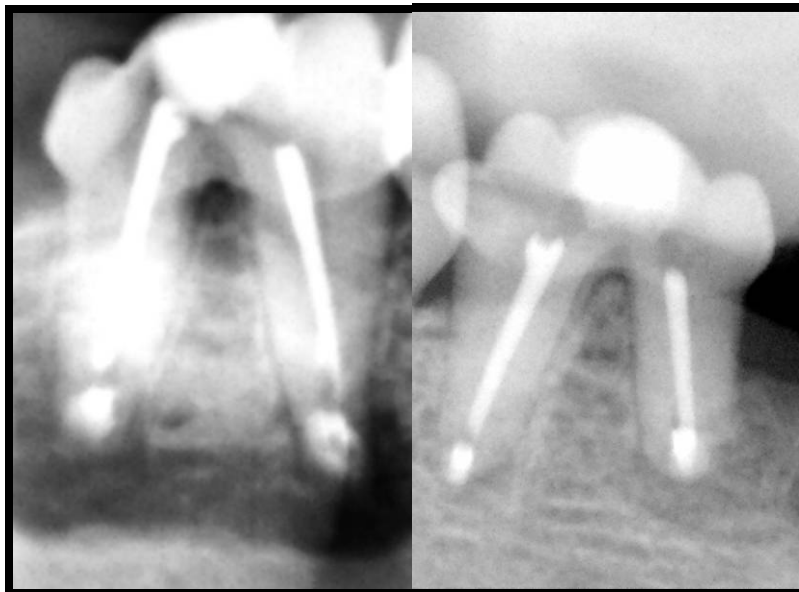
“Geristore tooth” radiographs post-surgical vs. 6 month follow-up 3
